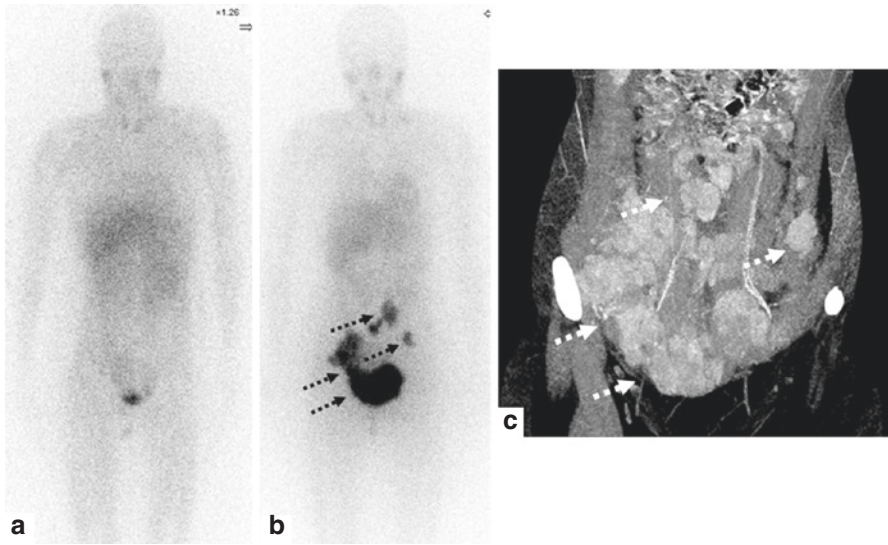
A 15-year-old female affected by NB soft tissue relapse. The patient, after achieving complete remission (a), at 1 year follow-up, showed multiple peritoneal localizations detected by ¹²³I-MIBG scan (b) and CT (c)
